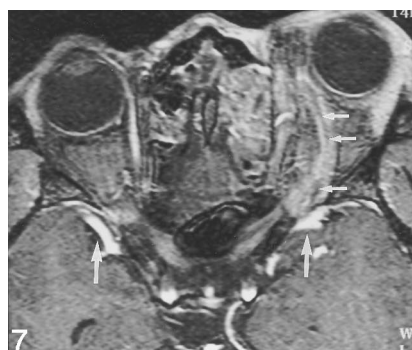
Contrast-enhanced SPGR MR image in 18-year-old man with progressive left-sided exophthalmos and chemosis shows linear filling defect in dilated left superior ophthalmic vein (short arrows). Note bilateral, predominantly left-sided ethmoidal inflammation and prominent but patent sphenoparietal sinus bilaterally (long arrows).
